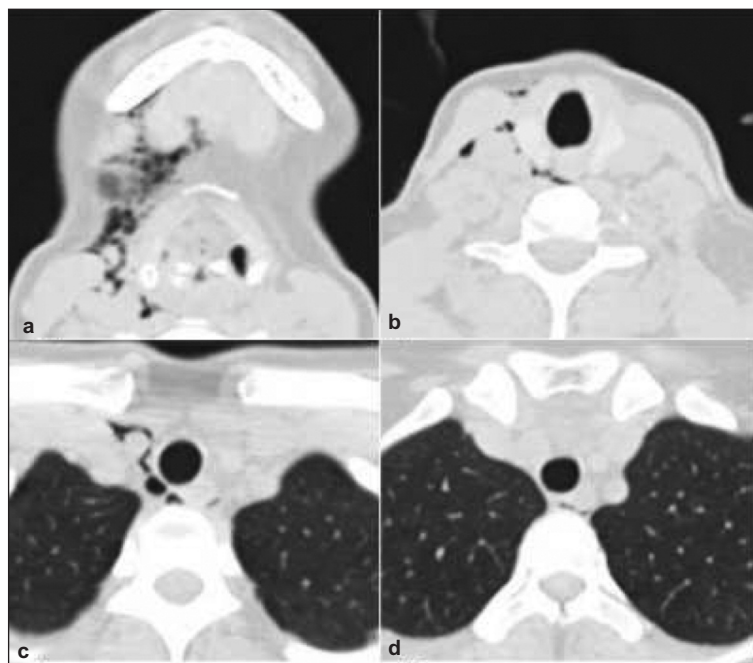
Computed Tomography (CT) scans of neck and chest revealing air densities in the soft tissues extending to mediastinum (Lung window set).
